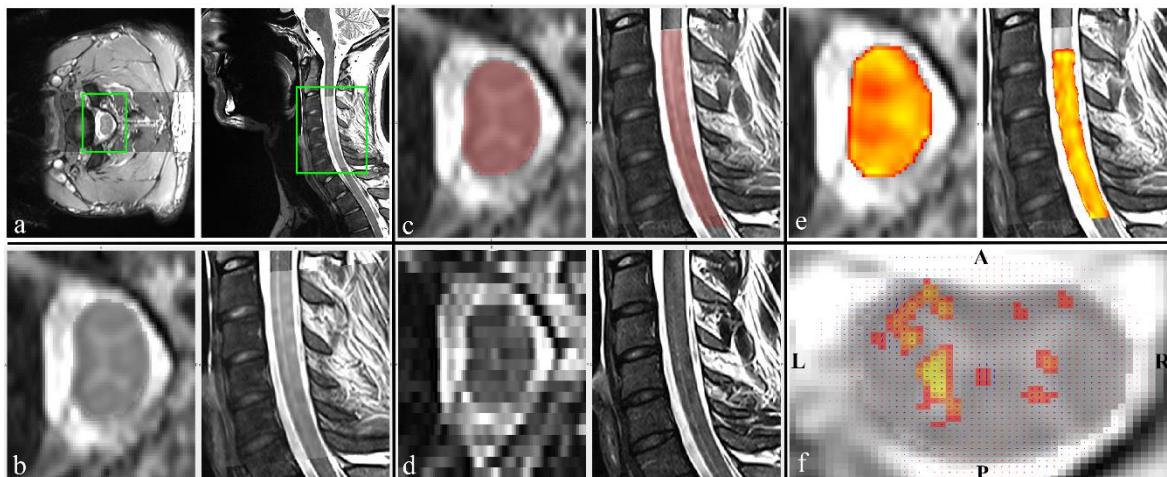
Single subject results: a represents T2-weighted anatomical fused high-res image, b is zoomed a, c shows spinal cord segmentation, d is T2-weighted sagittal image, e represents T2-weighted anatomical fused high-res image with ZOOMit HARDI dMRI FA map in anatomical space (red=0.3; yellow=0.9) and f is ZOOMit HARDI dMRI data with ball and stick model with 1st and 2nd fiber direction registered on T2 fused anatomical high-res image with partial volumes of 2nd fiber directions (red=0.05; yellow=0.28), which represents the percentile of the whole dMRI signal.
